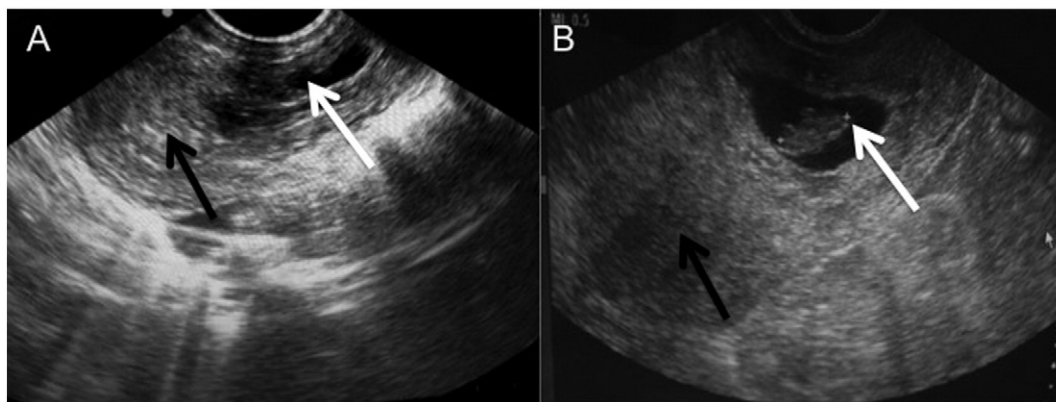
Transvaginal sonography imaging of the two types of CSP. (A) CSP type I: the gestational sac is implanted in the cesarean scar at the anterior uterine wall involving the cervico-isthmic space. (B) CSP type II: the gestational sac bulges toward the outer myometrium and is implanted in the cesarean scar at the anterior uterine wall. Abbreviation: CSP, cesarean scar pregnancy. White arrows indicate the gestational sac; black arrows indicate the empty uterine cavity.
